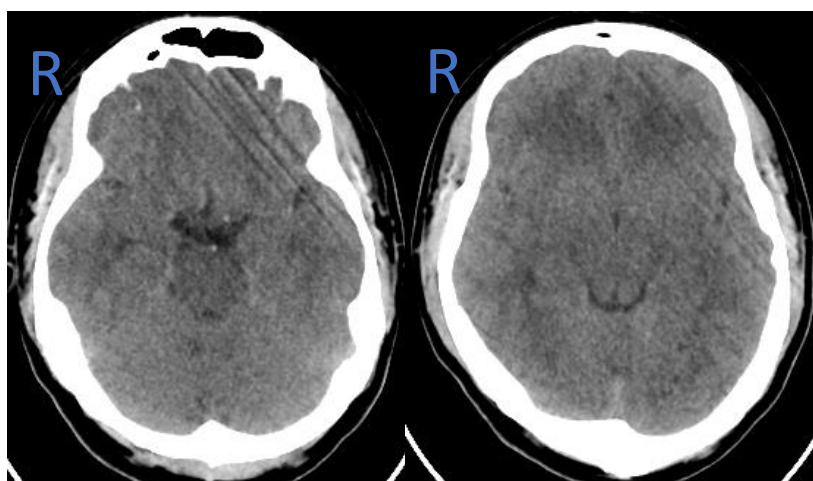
Head CT-Scan without Contrast Axial Section
